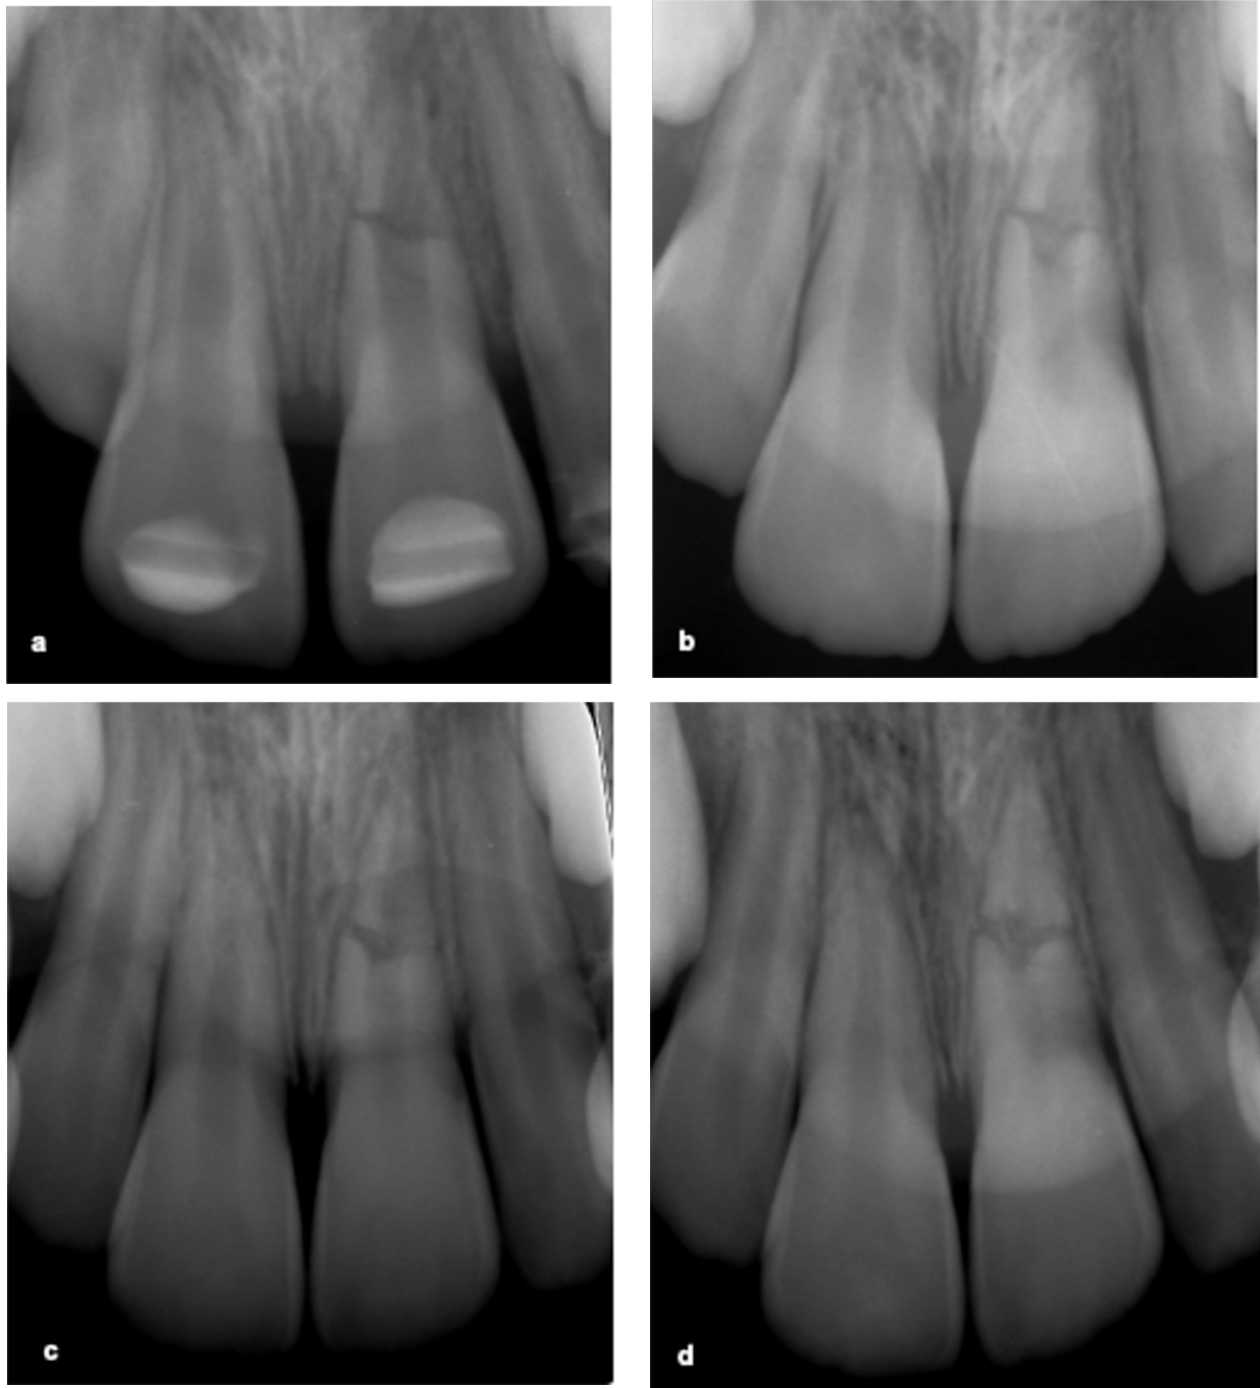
Radiographic follow-up at a) 4 weeks b) 3 months c) 6 months and d) 1 year
